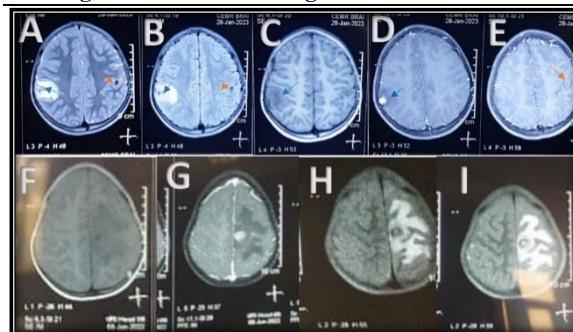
(case 5) [IMAGES FROM 2023] T2 (A), T1 (C) and FLAIR (B) showing low signal intensity suggestive of granular-nodular (blue arrow) and calcified (red arrow) stage of NCC with some perilesional oedema. Contrast enhancement (D, E) shows ring enhancing lesion (red arrow) and solid enhancing nodule (blue arrow) of NCC. [IMAGES FROM 2021] T1(F),T2(I),FLAIR (H) and post Contrast image (G) showing single conglomerated ring enhancing lesion of NCC in colloid-vesicular stage with extensive perilesional oedema.
